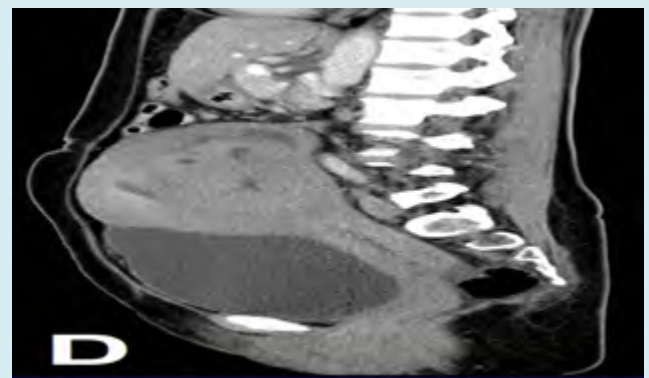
CT abdominal and pelvic with double contrast, sagittal view.
